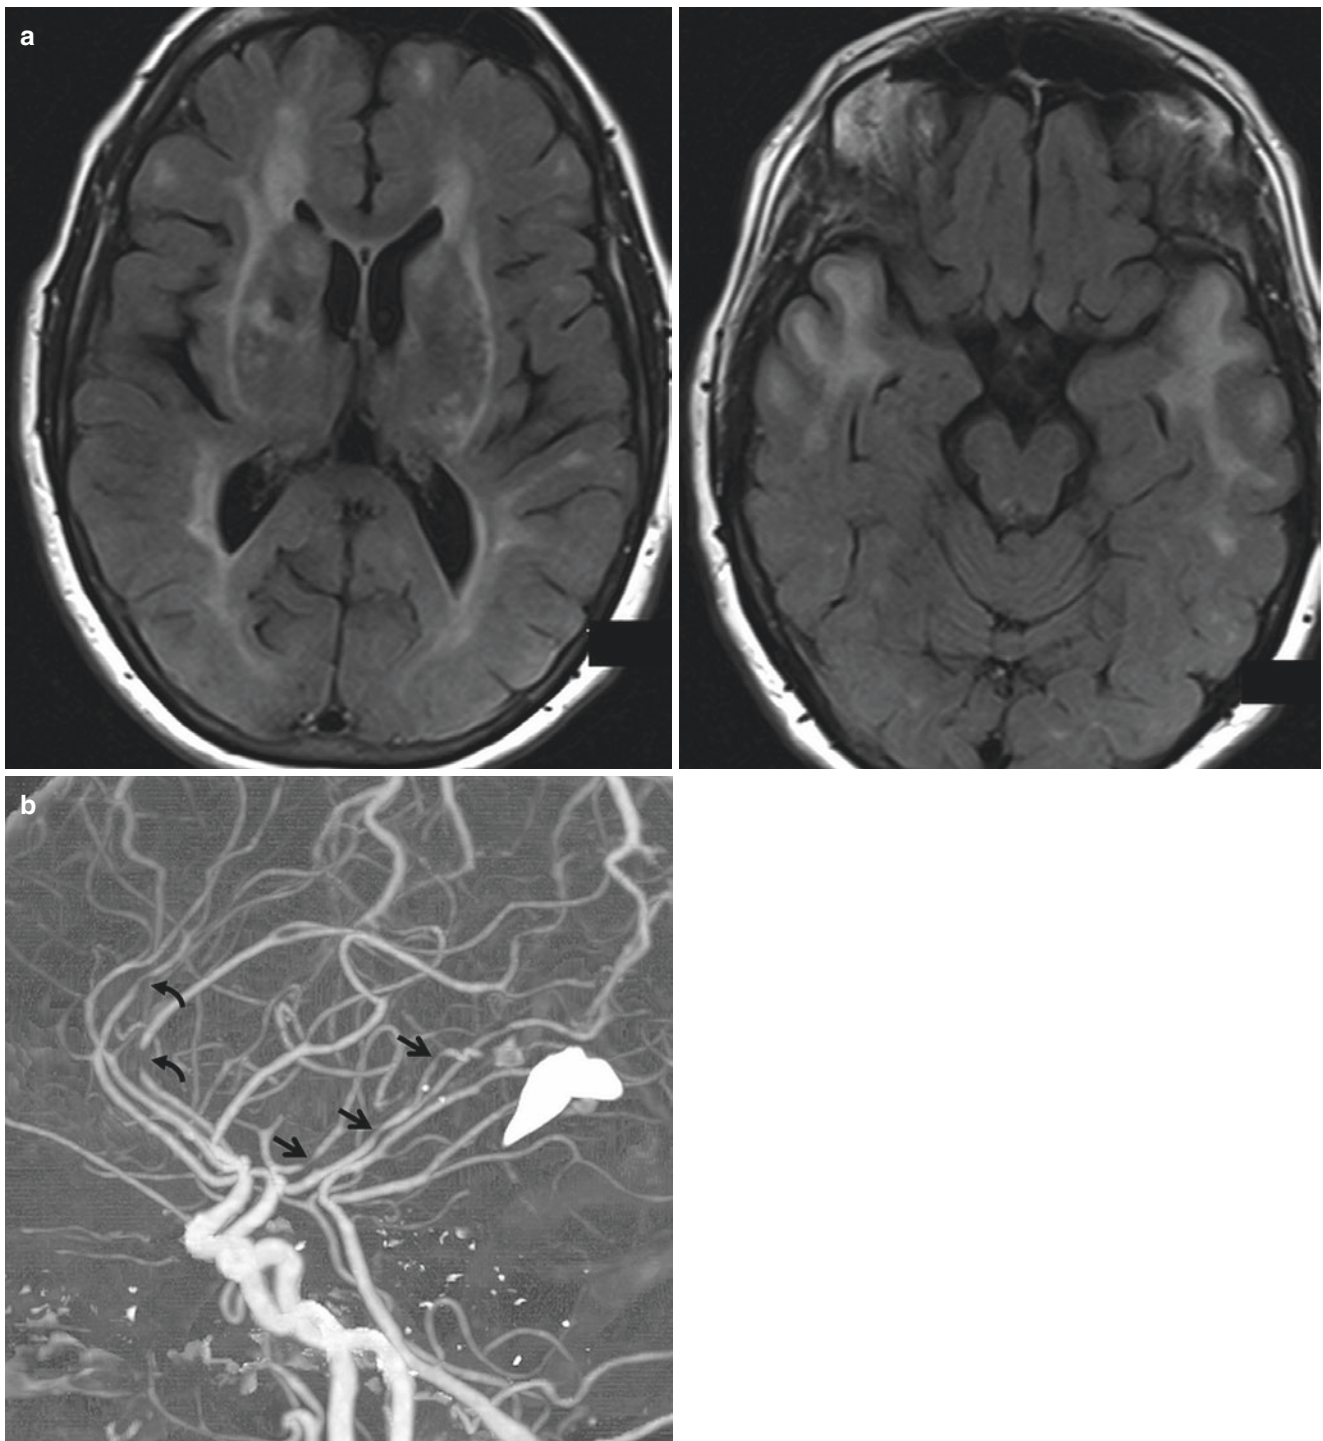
CADASIL. Patient with recurrent strokes and mental decline. (a) Axial FLAIR images show confluent white matter disease with symmetric involvement of external capsules and anterior temporal lobe
